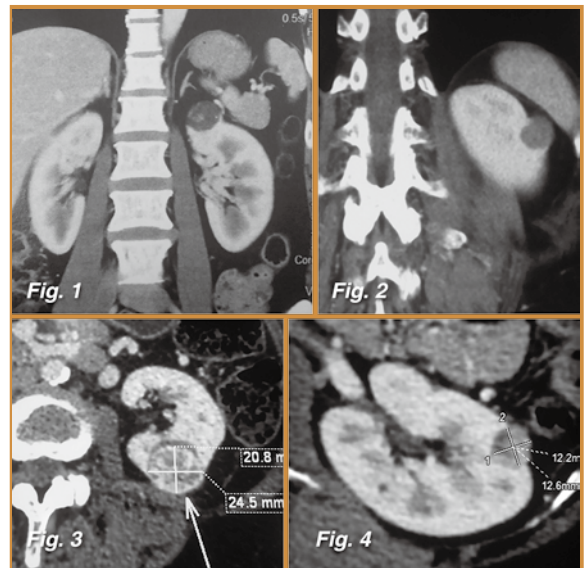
CT images of contrast enhancing small renal masses (Source: Almassi et al. management of the small renal mass)
